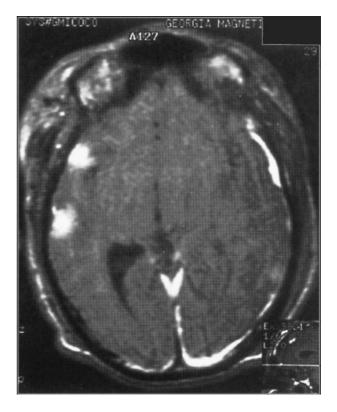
Brain MRI (axial T_1 WI) demonstrates redistribution of blood in the subdural space formatting a thin layer.
